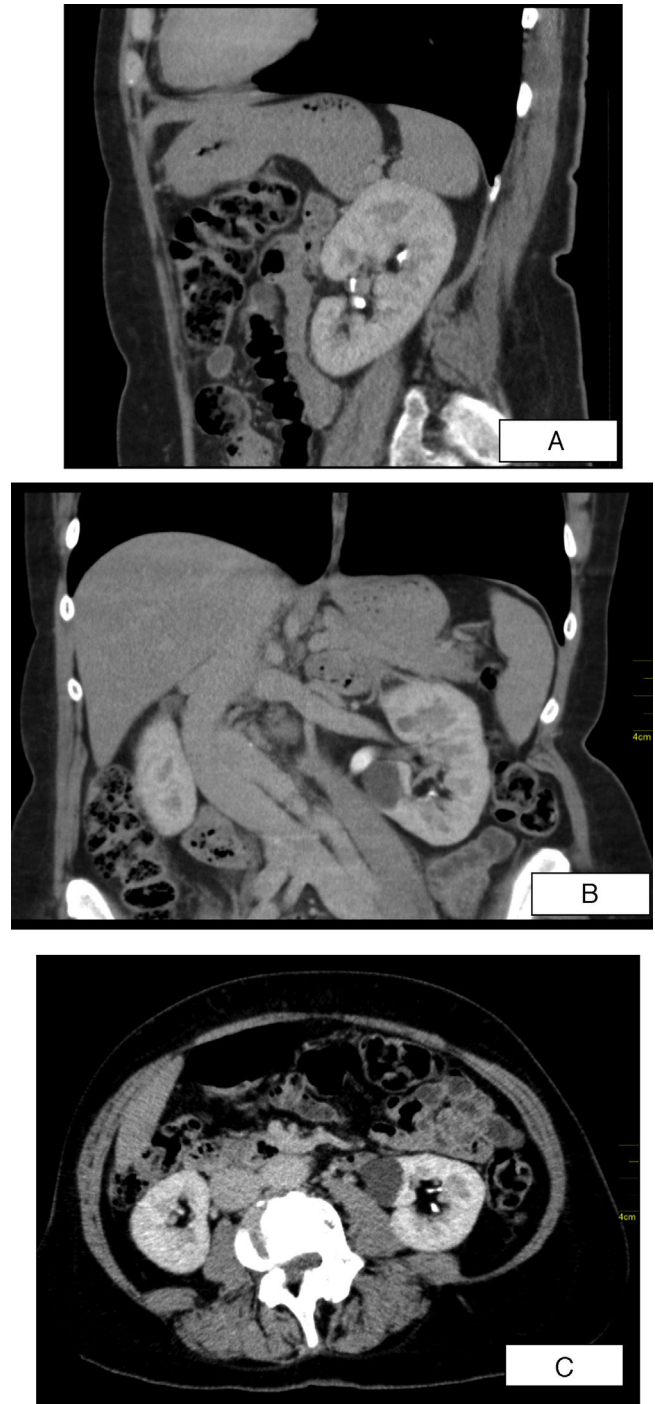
A, B, C: Sagittal, coronal and axial sections of abdominal computed tomography revealing structural heterogeneity of the left renal parenchyma with diminished enhancement at the tip of the medullary pyramid and the presence of small cavities filled by contrast on the borders of the small calices – aspects highly suggestive of papillary necrosis ischemia.
